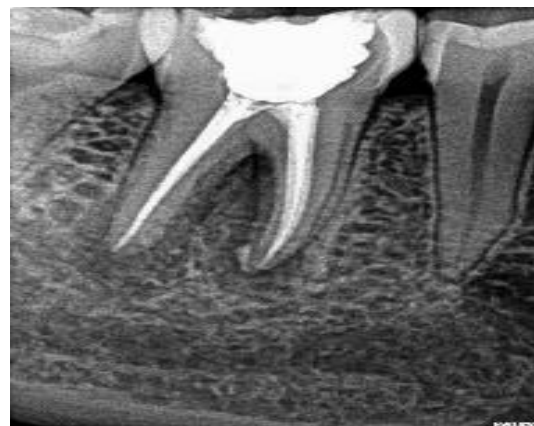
radiograph at 3 months follow-up
